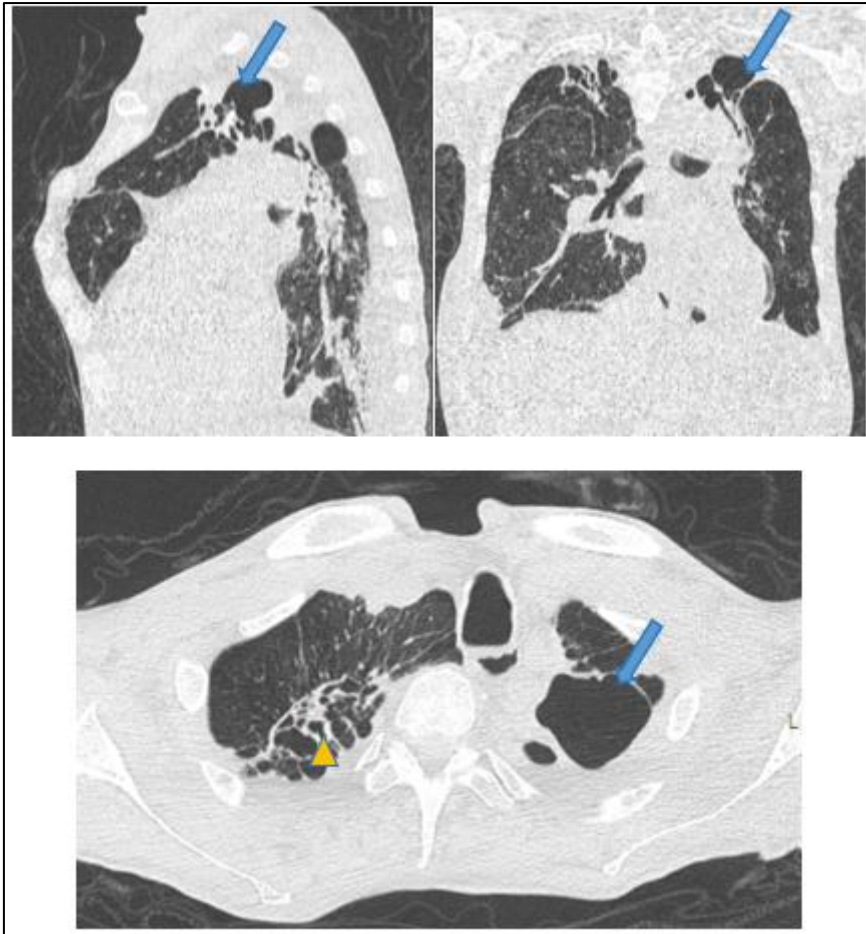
CT pulmonary angiography lung window showing a thick-walled cavitary lesion in the left upper lobe apex (arrow), associated with bilateral cylindrical and cystic bronchiectasis predominantly involving the upper lobes (arrow head)
